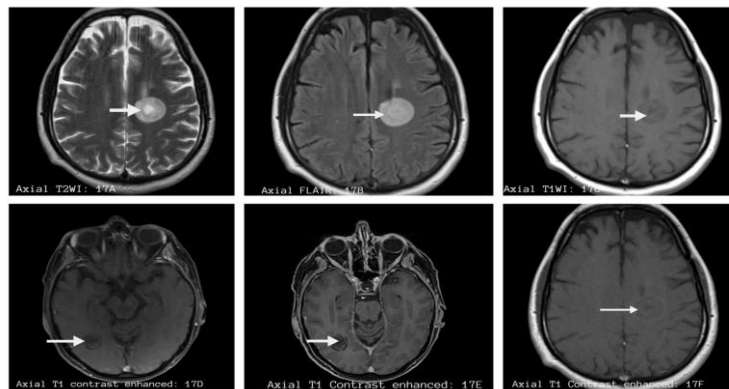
Irregular concentric hyperintense lesions seen on T2WI (17A) and FLAIR (17B). Iso to hypointense lesion seen on T1WI (17C). Figures (17D), (17E), and (17F) showing peripheral ring enhancement in areas of active demyelination.
